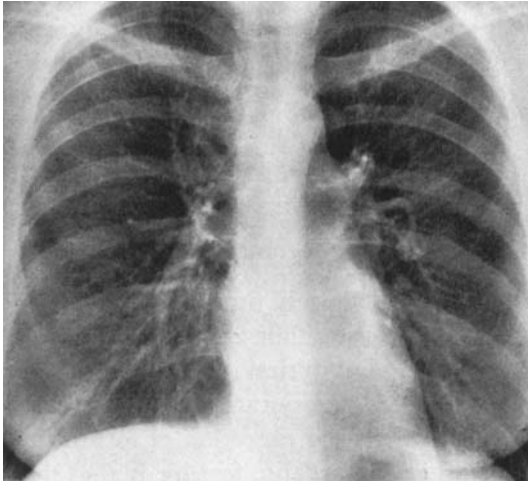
Case 2. Lung roentgenogram (R 4 in fig. 11). The metastatic lesions have regressed.
